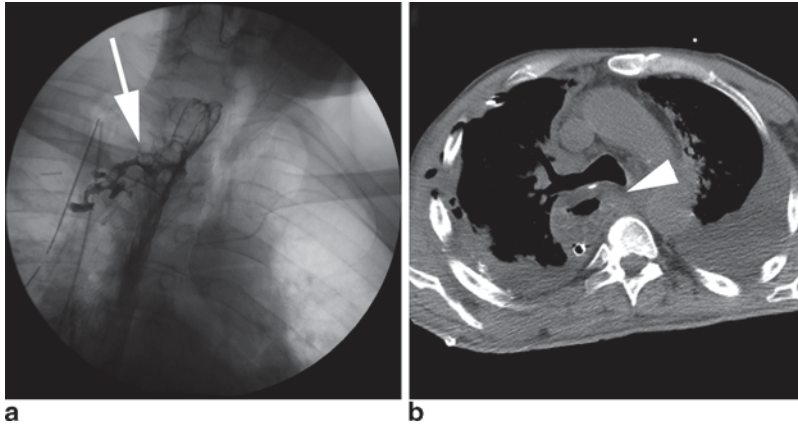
Commonly used imaging studies to evaluate for an anastomotic leak include contrast esophagram (a) and CT scans (b). Esophagrams may show contrast extravasation freely into the chest or into a contained leak (arrow).
